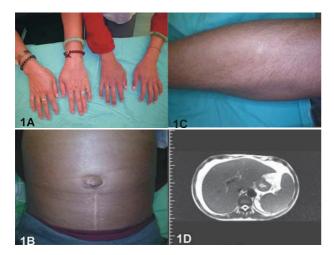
Diffuse hyperpigmentation and sclerodermoid changes of bilateral hands, white fingernails were noted compared with her mother (left side) (1A), the same skin changes were also noted at abdomen (1B). Hypertrichosis of right lower leg was found (1C). Coronal T2 weighted magnetic resonance images showed massive ascites and splenomegaly (1D).
